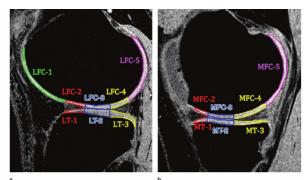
Morphological MRI Processing; Gupta 2014
